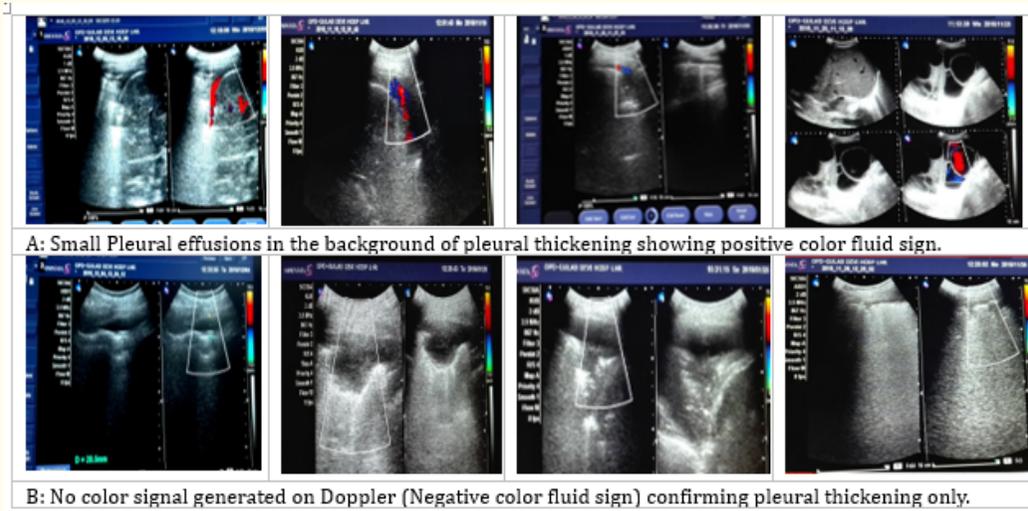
Sonographic morphology by gray-scale and color doppler ultrasonography.
